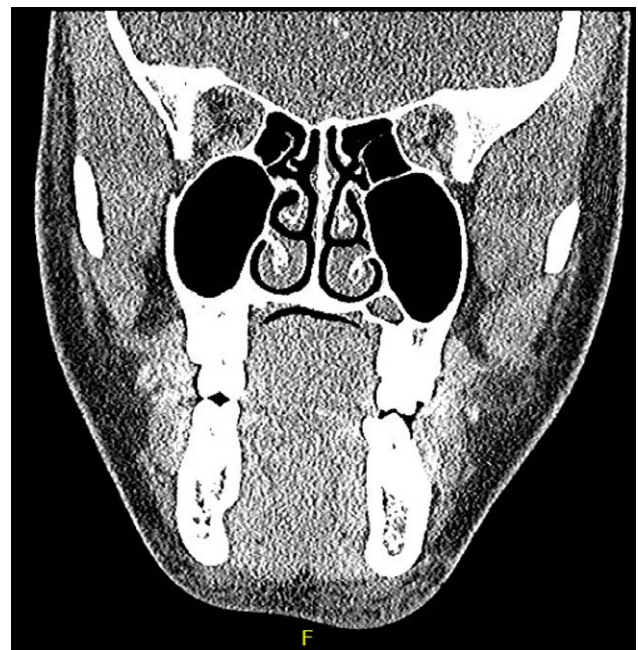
This is an 18-year-old African American woman who presents with painful, fast-growing submandibular masses. CT findings of nondescript soft tissue fat stranding shown in the image.
